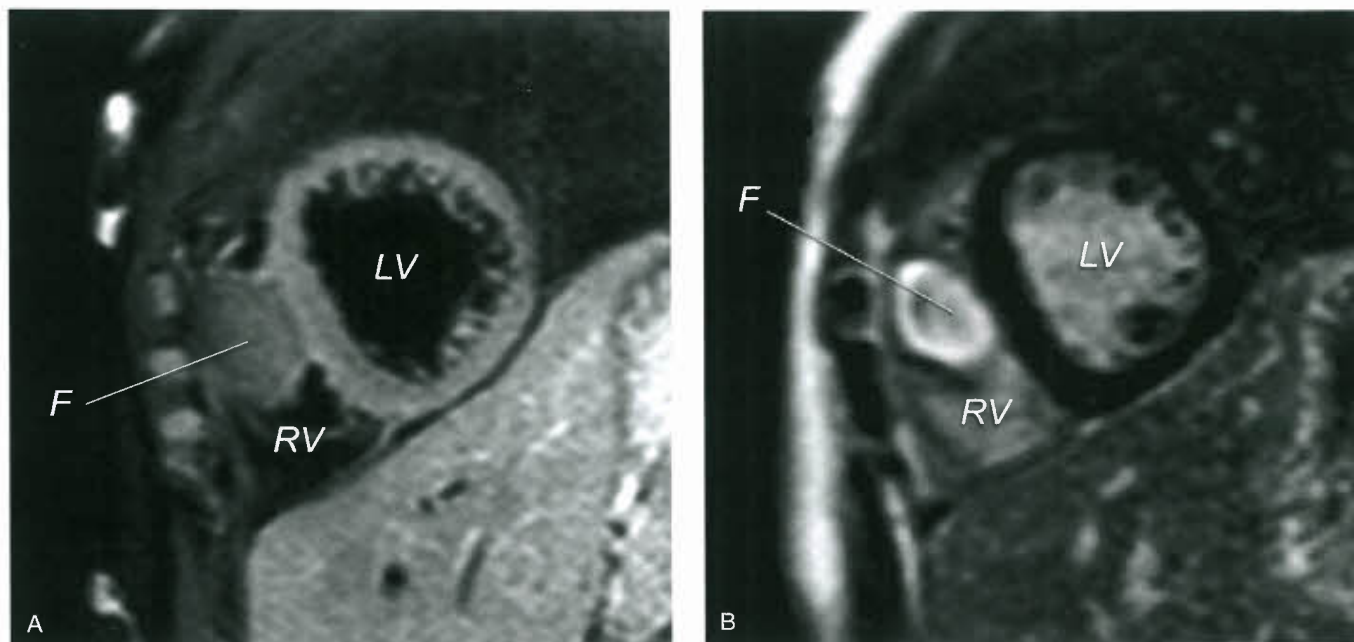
A: Spin-echo MRI from a child with a large right ventricular fibroma (F). B: Gadolinium-enhanced MRI, from same child, demonstrating uptake within tumor mass. This uptake indicates fibrous tissue, consistent with a cardiac fibroma. LV, left ventricle; RV, right ventricle. (Courtesy of Tal Geva, M.D., Department of Cardiology, Children's Hospital, Harvard Medical School, Boston, MA.)
